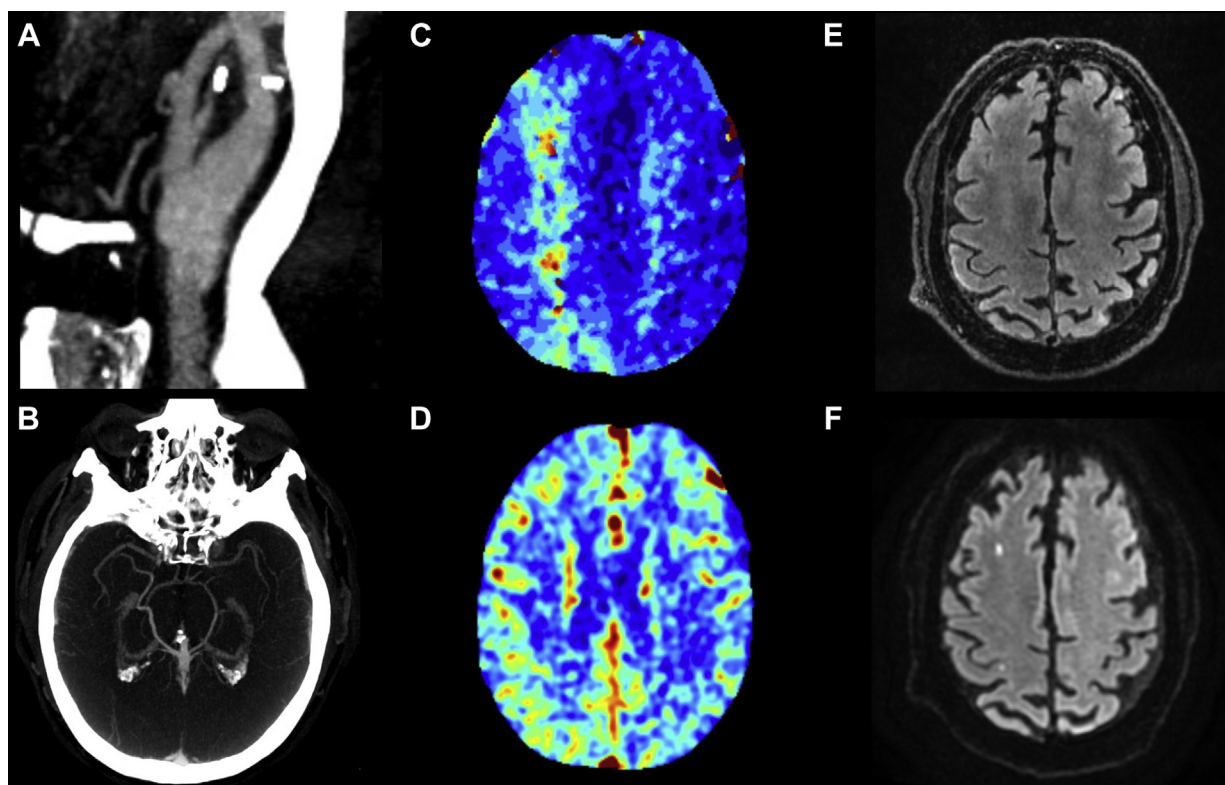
Computed tomography (CT) angiography performed after the patient was transferred to a tertiary care center for further evaluation revealed a patent carotid bifurcation with no evidence of local postprocedural complications (A). Computed tomography angiography of the head was notable for the absence of middle cerebral artery branch vessels in the right Sylvian fissure (B). CT perfusion imaging revealed elevated mean transit times in a watershed territory of the right middle cerebral artery (C) with preserved symmetrical cerebral blood volume (D). Follow-up magnetic resonance imaging showed no abnormal T2-weighted/fluid-attenuated inversion recovery (FLAIR) signal in the absence of cerebral edema (E). Diffusion imaging revealed areas of focal small infarcts in watershed territories (F).
